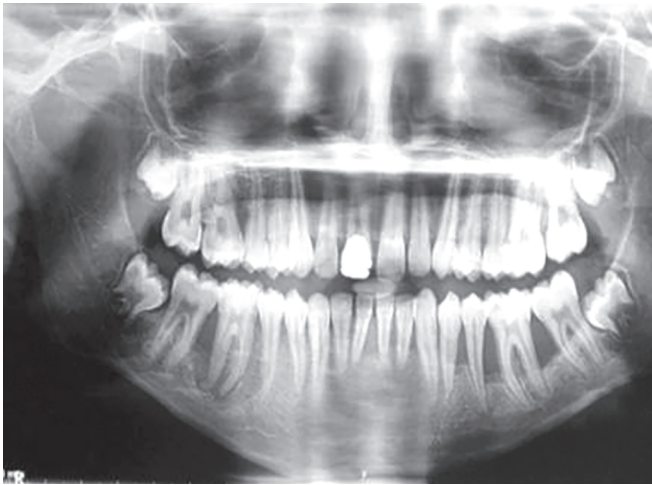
Orthopantomogram reveals osteolytic lesion wrt 36 46
